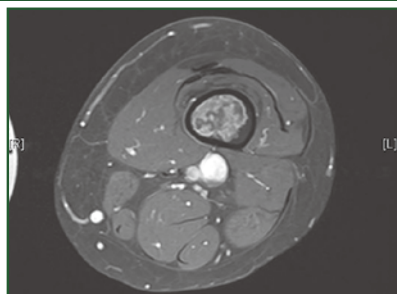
Gadolinium-enhanced T1W axial MR image with fat saturation on the same lesion. The lesion shows contrast enhancement, with no associated endosteal scalloping, periosteal reaction or extra-osseous extension.
